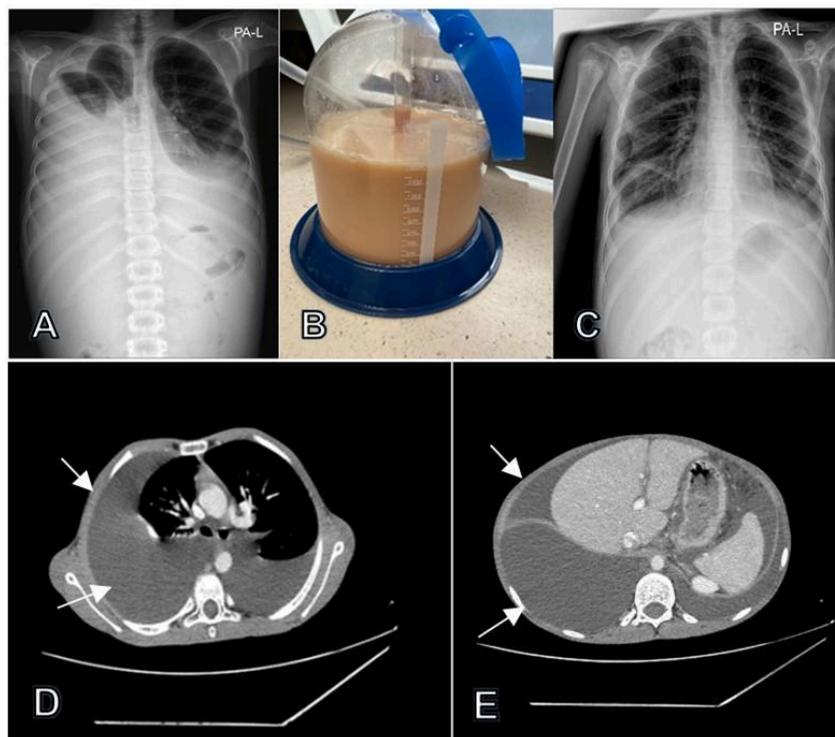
Chest radiograph (A: at presentation, C: day 20) and pleural fluid appearance (B: at presentation). Thoracic (D) and abdominal (E) CT scans obtained at presentation.
